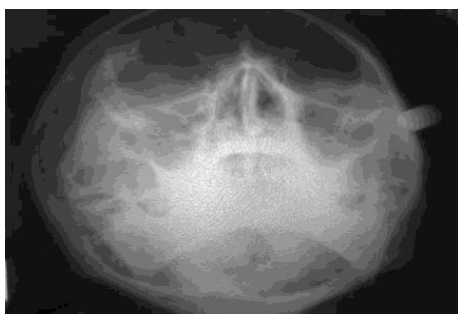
X-ray - Paranasal sinus view of patient's skull.
